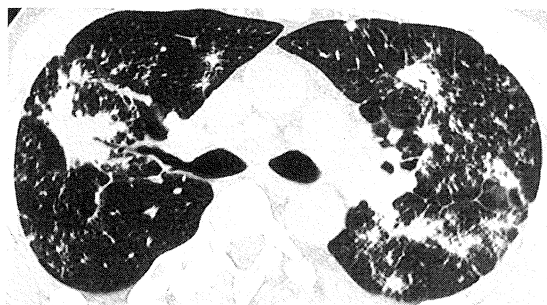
1.5 mm HRCT scan of the upper lobes shows multiple, bilateral nodules of varying sizes. Note the presence of an air bronchogram in the right upper lobe conglomerate mass.
